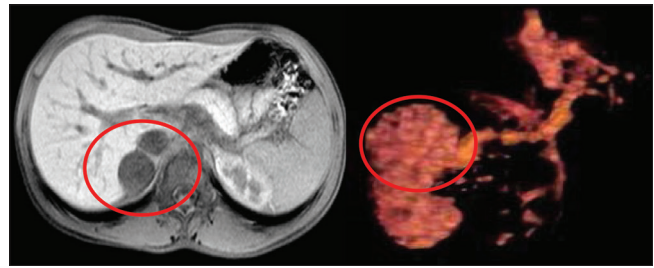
Magnetic resonance imaging: The adrenal lesion and processing three-dimensional of images
